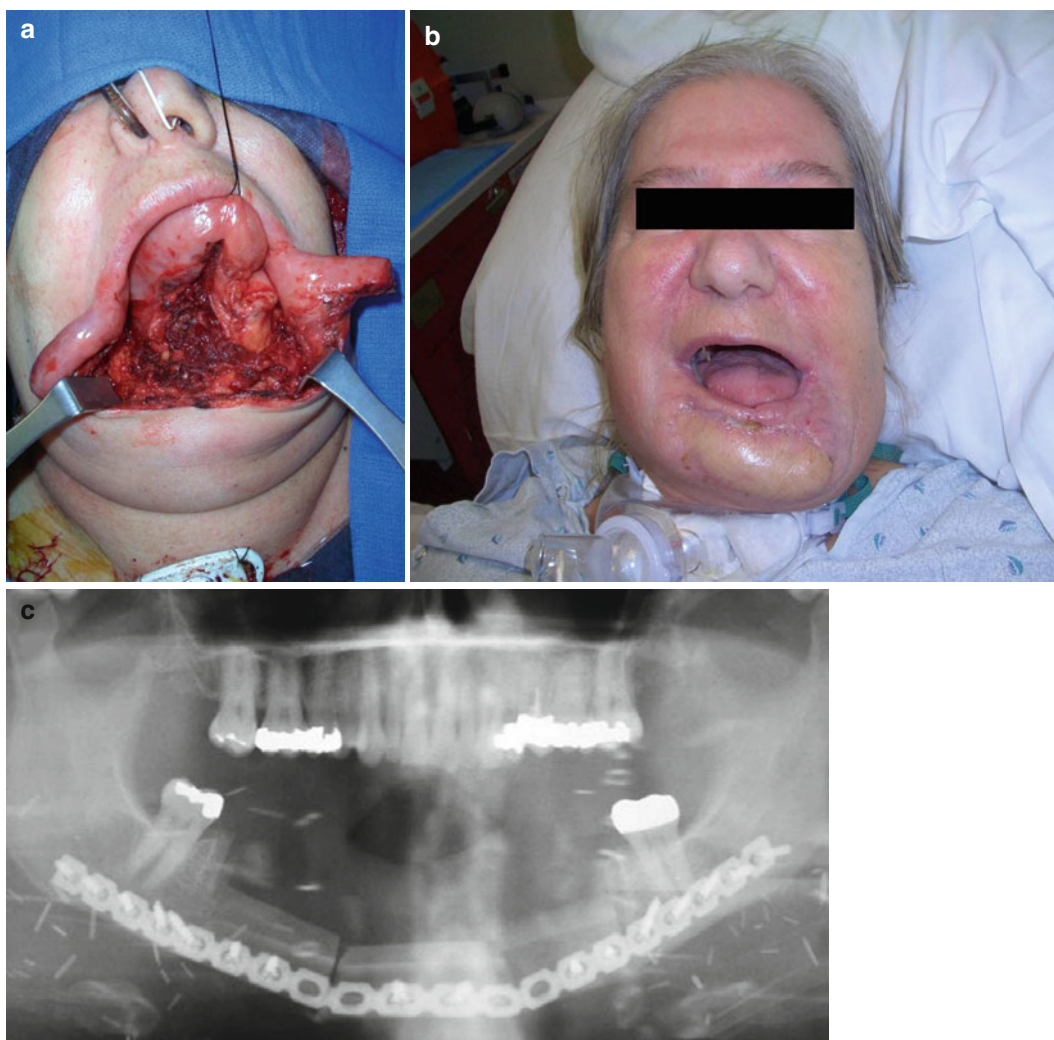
Reconstruction of mandibular and soft tissue defect after resection of a mandibular ameloblastoma (a). Plain film demonstrates the bony segment of the fibula osteoseptocutaneous flap used for
